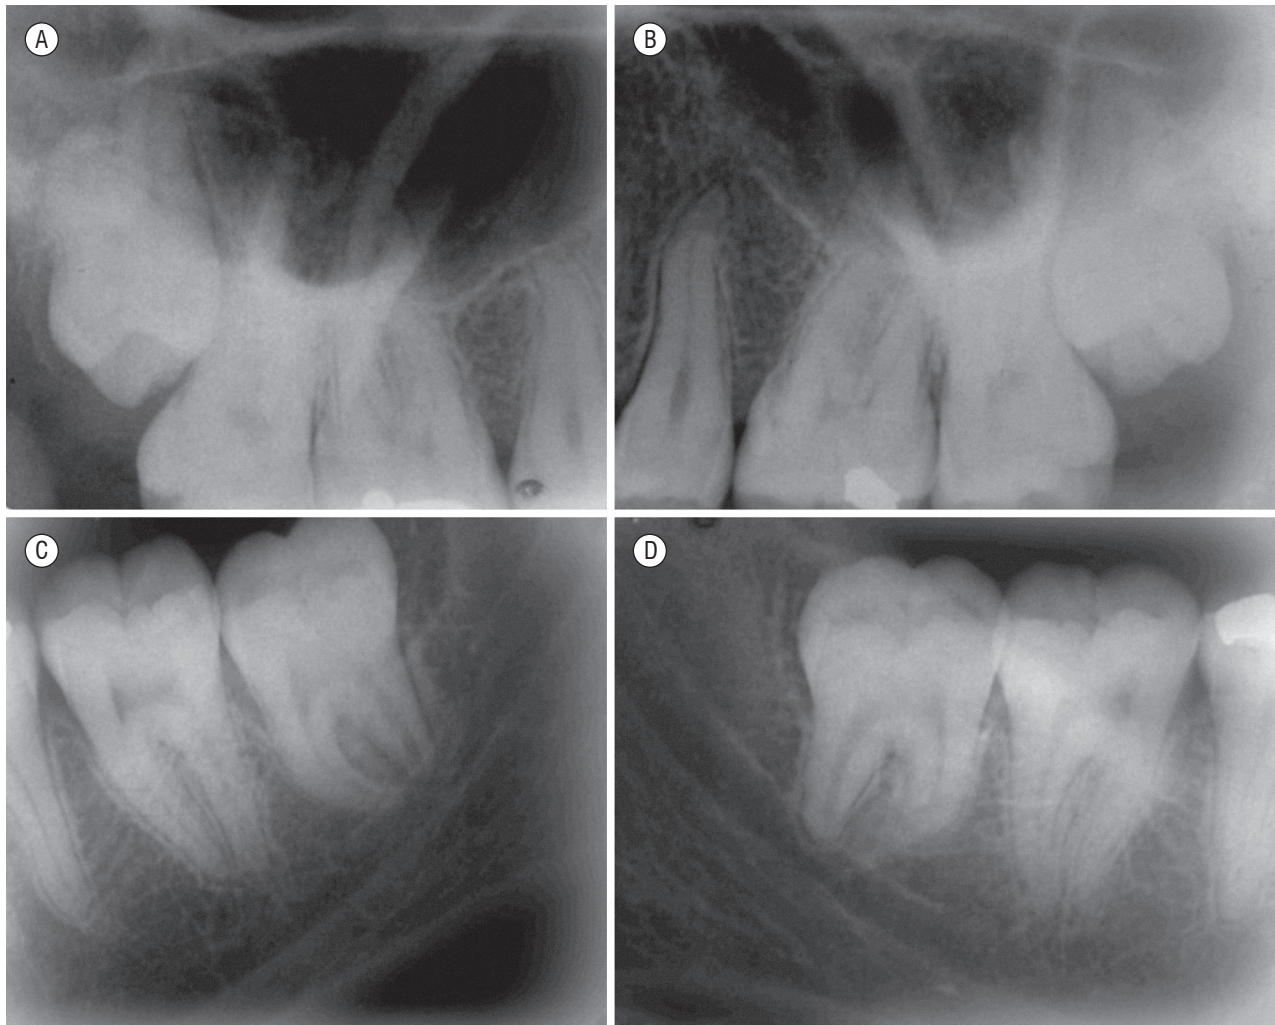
Periapical radiographies of third molars presenting a delimited well unilocular pericoronal area, suggesting pericoronal follicles
